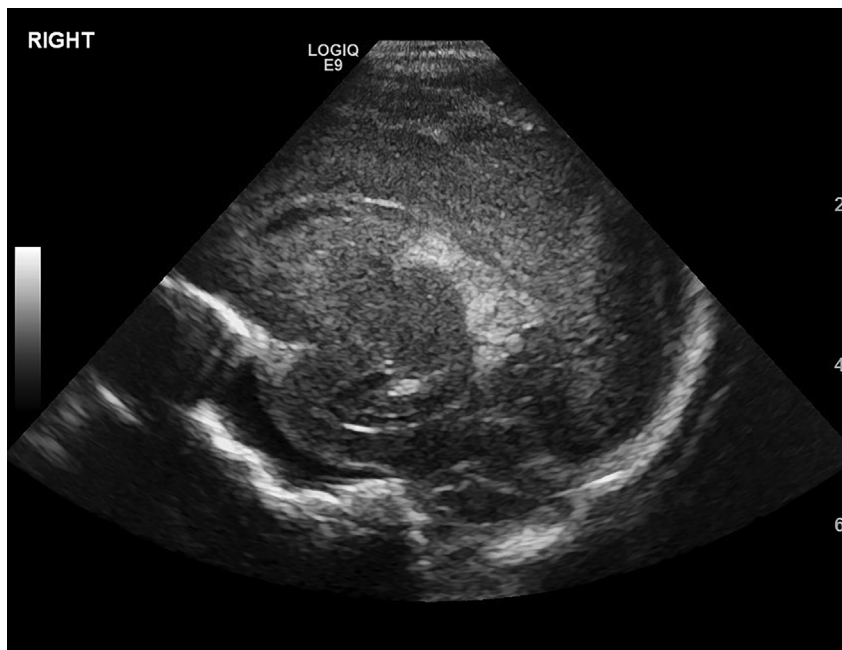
Sagittal view: blood occupying less than one-half of the right ventricular area at first ultrasound investigation, with no chamber dilatation.
